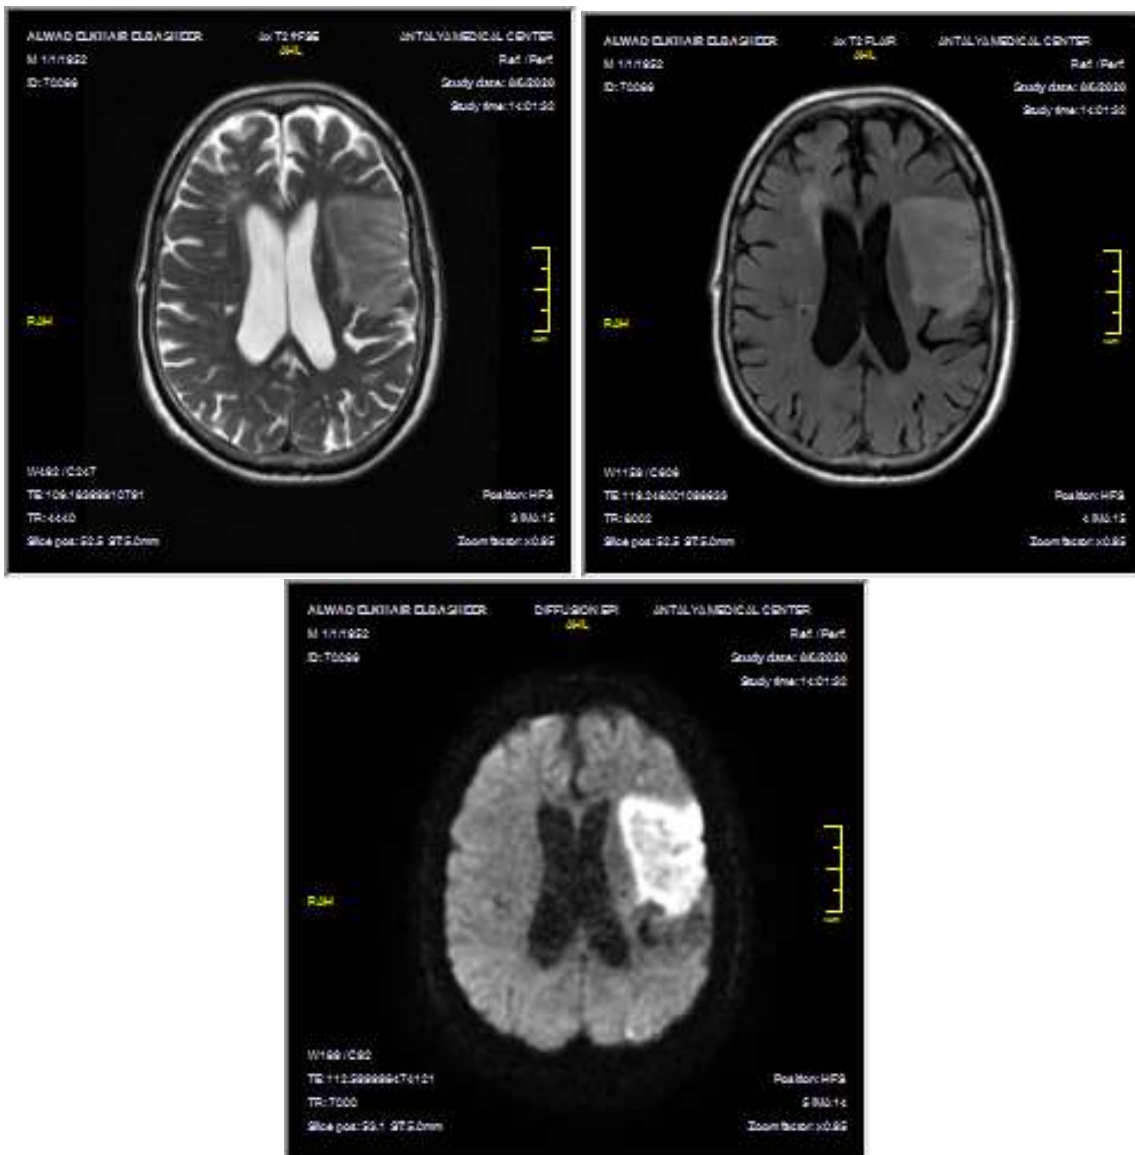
Hyperintense signal on T2, FLAIR, and DWI observed at the left temporal and occipital region. DWI, diffusion-weighted MRI; FLAIR, fluid-attenuated inversion recovery.
